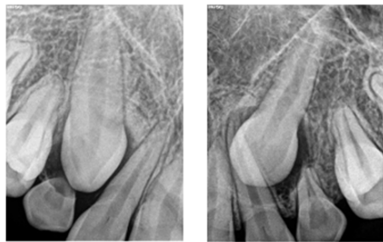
Figure e: Initial periapical radiographs.
